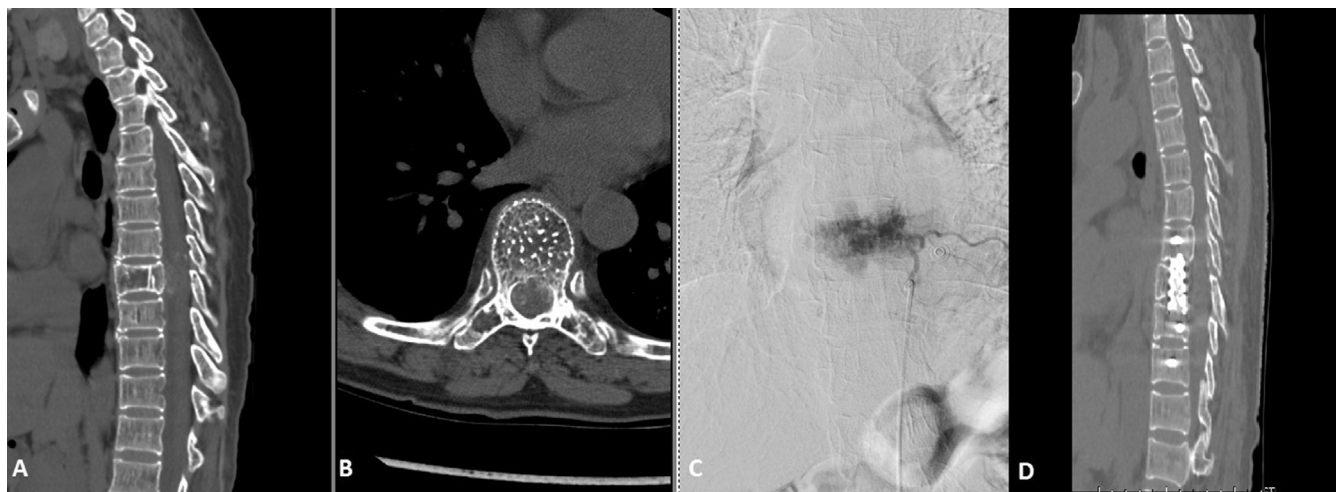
CT thoracic spine showing (A) lytic change in the T8 body; (B) “polka-dot” appearance of the body and multiple lucencies; (C) spinal angiogram showing the tumour blush; and (D) postoperative CT showing the cage and pedicle screws in situ.
